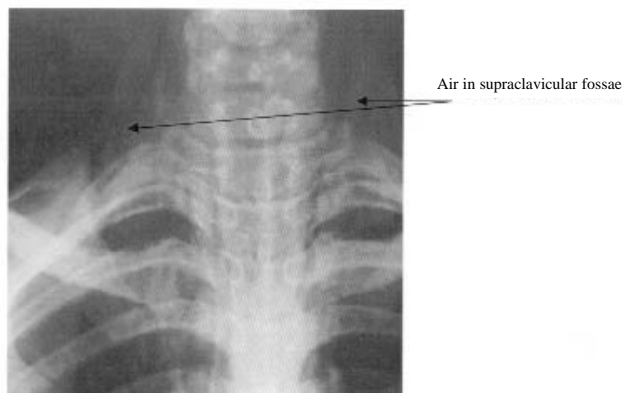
Chest radiograph demonstrating air in supraclavicular fossae.
